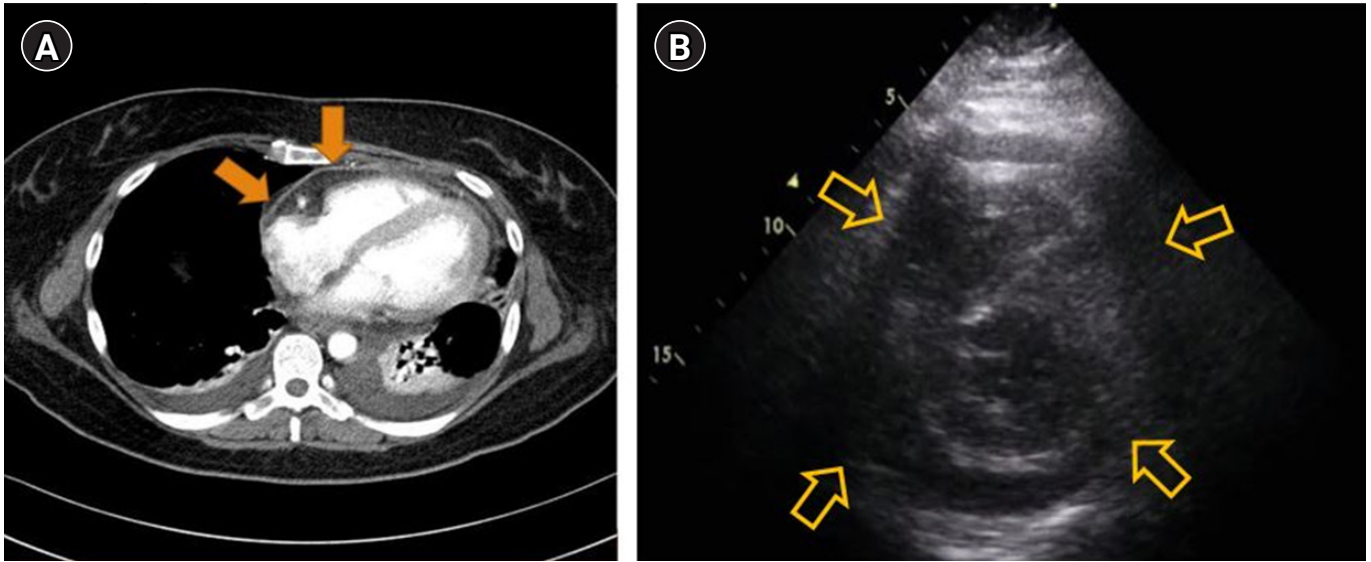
The image of cardiac complications. (A) Chest computed tomography shows pericardial effusion with pericardial enhancement (filled arrows). (B) Echocardiography shows marked pericardial effusion (hollow arrows).
